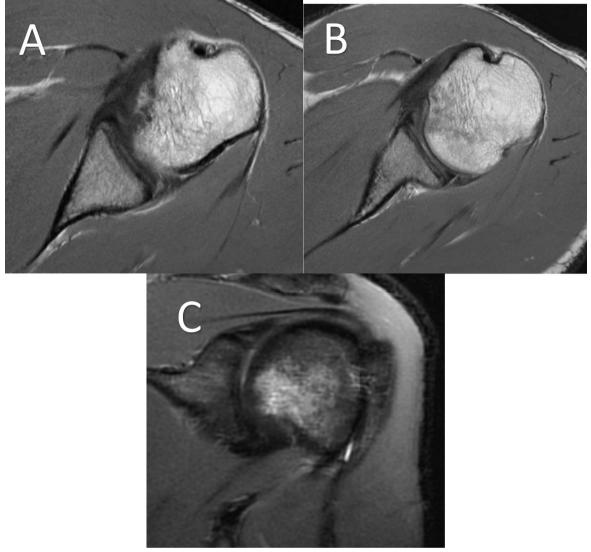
MRI of 21 year old baseball player with posterior shoulder pain after swinging a baseball bat. A. Axial MRI image demonstrating reverse Hill-Sachs lesion. B. Axial MRI image demonstrating
